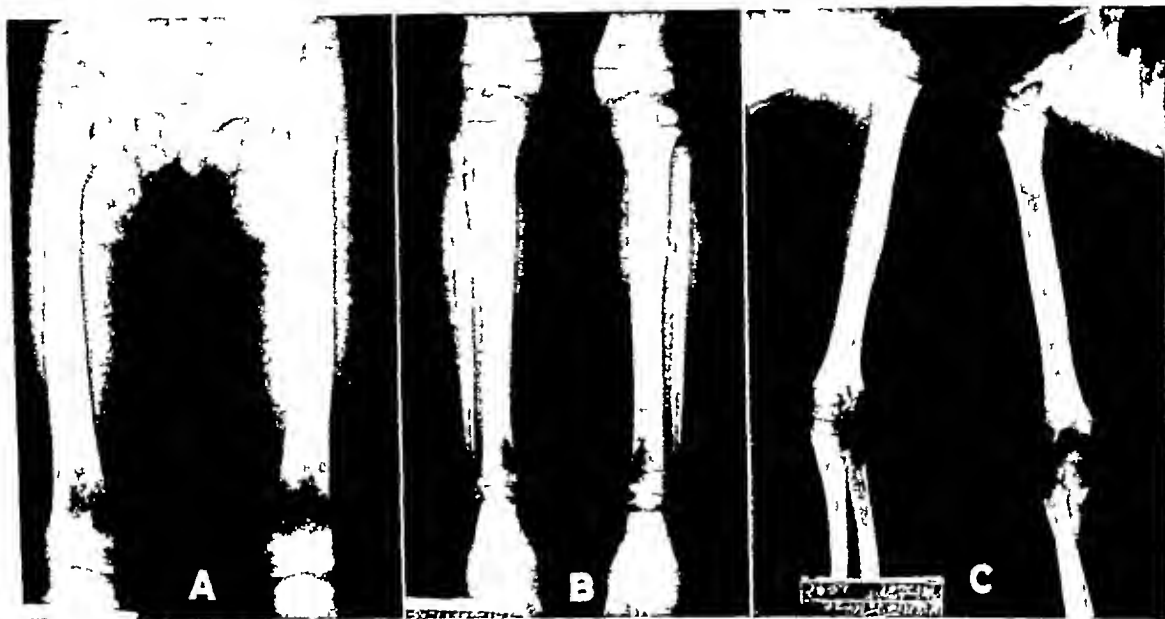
Case 4 N P Roentgenograms showing moderately early involvement of diaphyses of the long bones. There was also early involvement of the base of the skull with skeletal involvement as shown in Fig 2 A
